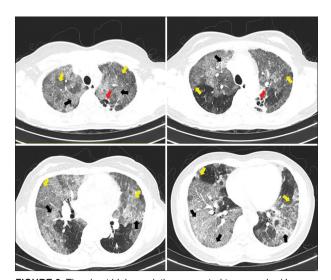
The chest high-resolution computed tomography (January 2020) showed ground-glass opacity (yellow arrows) with reticulation changes (black arrows), a combination known as crazy paving pattern, and cavities on the upper lobe of the left lung (red arrow).
